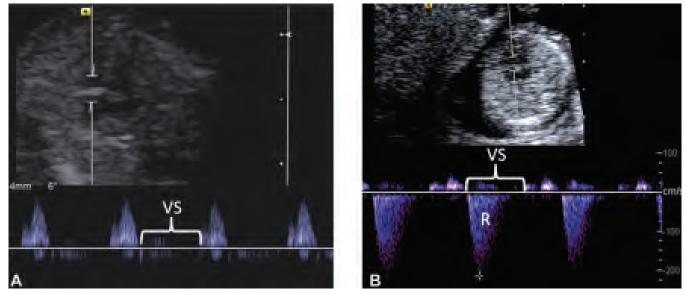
Tricuspid valve and ductus venosus Doppler waveforms demonstrating temporal relationship between normal and abnormal findings during the cardiac cycle. (reproduced with permission from ref. 228)
